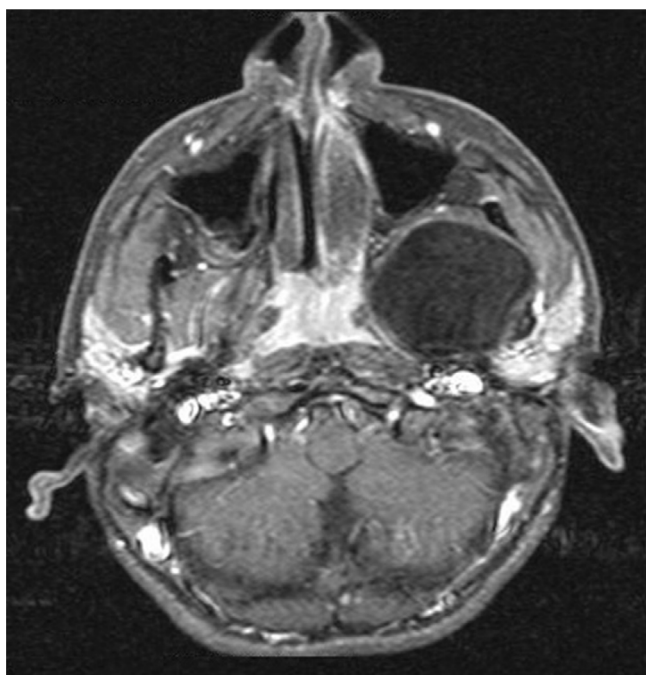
T1-weighted axial MRI. The hypointense cystic lesion compressed the posterior wall of the left maxillary sinus anteriorly.
